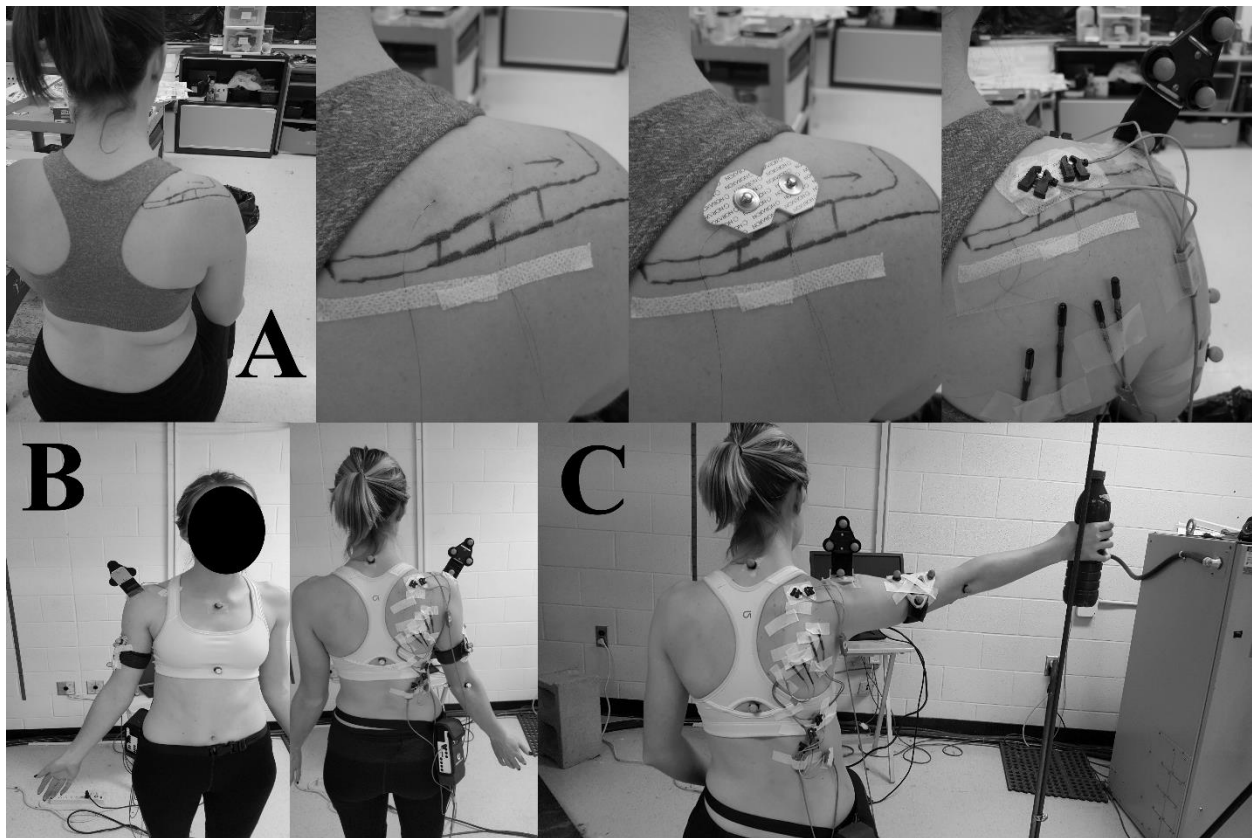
Experimental setup. Two indwelling electrodes were placed into the anterior and posterior supraspinatus with ultrasound guidance (A), then a bipolar surface electrode was placed on the supraspinatus muscle belly. Motion capture markers were placed over bony landmarks of the torso and right upper extremity (B). Participants completed arm elevations to maximal angle at a fixed cadence in differing planes of elevation with differing hand loads. A guide rail was used to indicate plane of elevation for participants during experimental trials (C).
